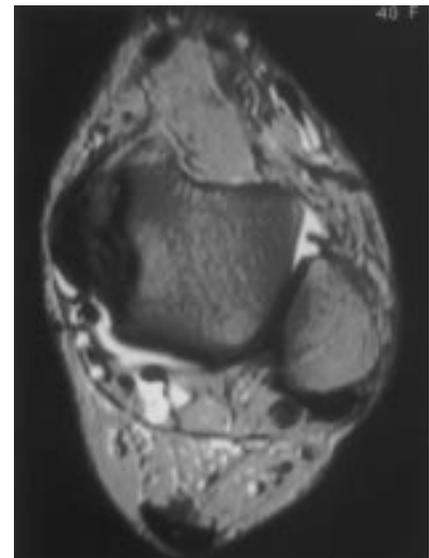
Axial T2-weighted MR image shows fluid in the lateral gutter with torn remnant of syndesmosic ligament.
